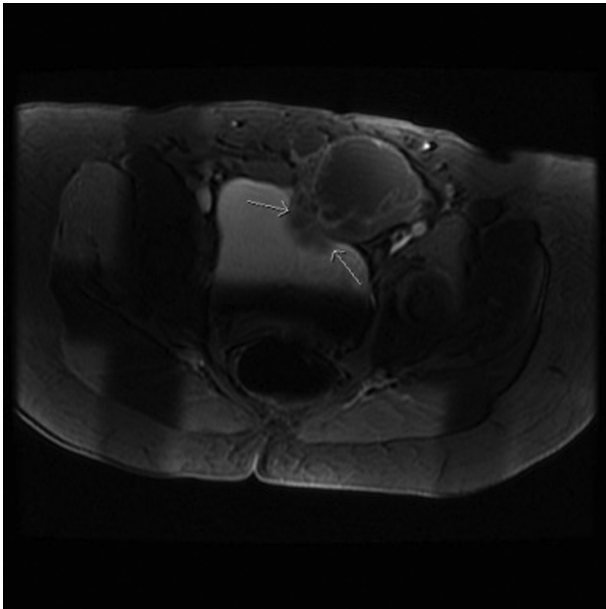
T1 FS postcontrast axial MRI image through the pelvis showing enhancing septations within the mass lesion anterior lateral to the urinary bladder.
